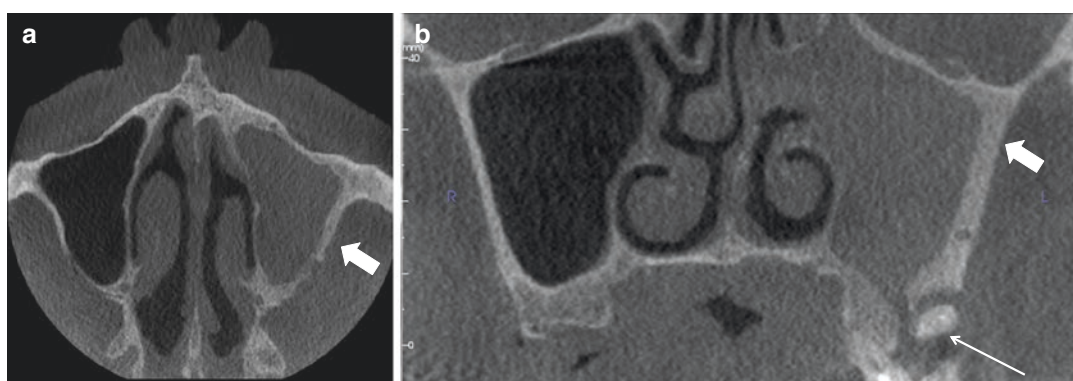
Coronal CBCT images of four different patients (a-e) showing different degrees of incidental inflammatory changes in the maxillary sinuses of asymptomatic patients: unilateral left maxillary and ethmoid
